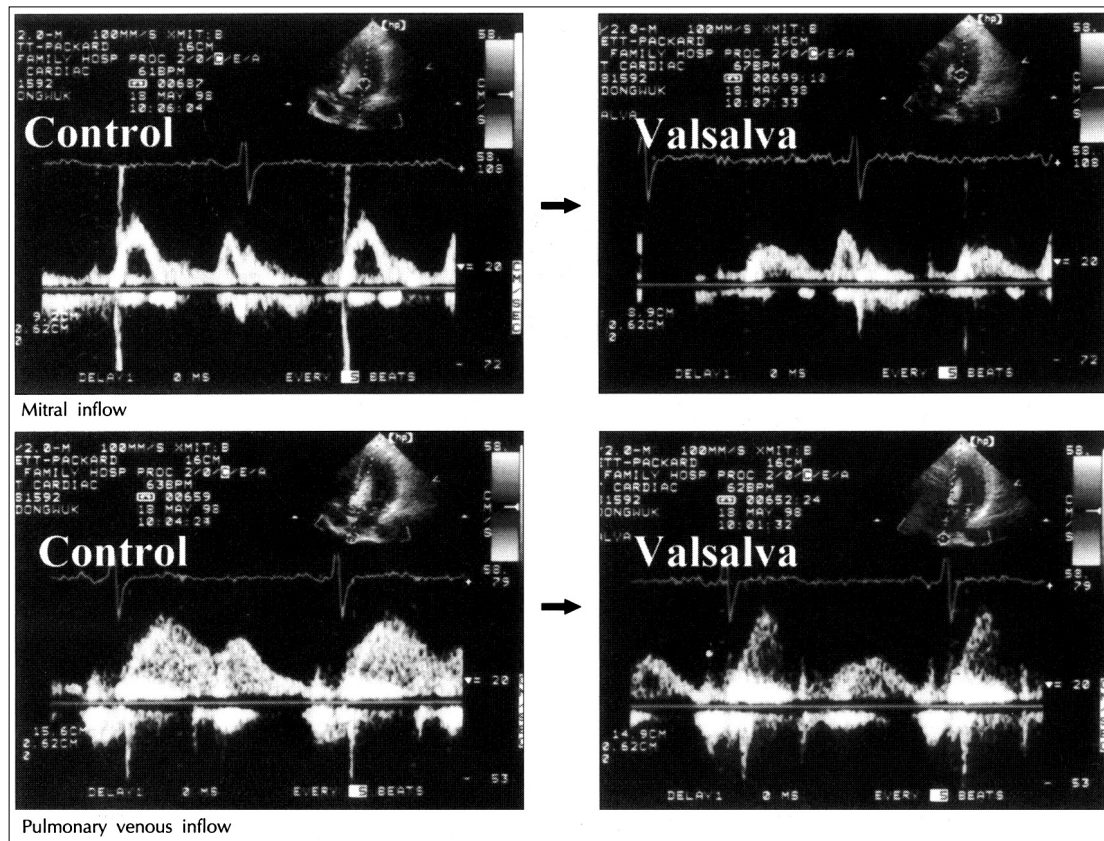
Transmitral and pulmonary venous Doppler recordings at baseline (left) and at peak strain on Valsalva maneuver (right) in pseudonormal group. Top, Transmitral Doppler recordings. E velocity was markedly decreased and A velocity was slightly increased, so the E/A ratio was <1.0 after Valsalva maneuver. Bottom, Pulmonary venous Doppler recordings. S velocity was slightly increased and D velocity was markedly decreased and the S/D ratio was markedly increased. Both changes during Valsalva revealed masked LV relaxation abnormality pattern.
